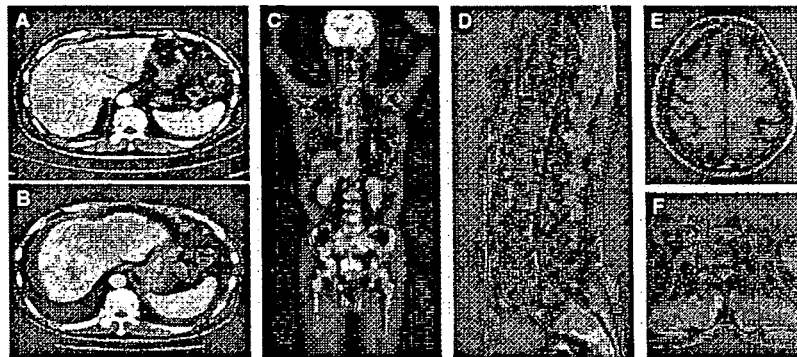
Computed tomography (CT) scan before chemotherapy shows heterogeneous low-density masses in bilateral liver lobes (A). On CT 2 months later, severe atrophy of the right liver lobe and an increase of the number and the size of multiple, bilateral masses is seen (B). FDG-PET shows heterogeneous FDG accumulation in the systemic spine, pelvis, and femora, as well as a hot spot in S7 of the liver (C). MRI examination of the spine and head shows heterogeneous intensity on T2-weighted images with gadolinium enhancement, suggesting progressive marrow replacement by the tumors (D–F).
